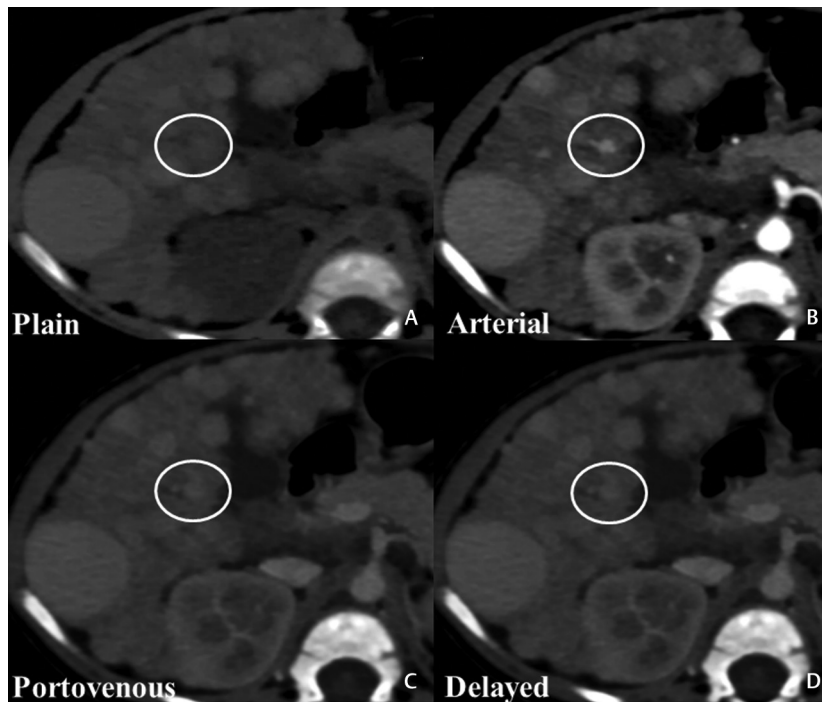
Sequential axial CT scan through the liver at a lower level. Axial noncontrast (A), arterial phase (B), equilibrium phase (C), and hepatic phase (D) images are shown. A small isodense, ill-defined observation seen in segment IVb of the liver (encircled). It shows nodular nonrim arterial phase hyperenhancement, showing subsequent washout and appearing isodense to the normal liver parenchyma on equilibrium and hepatic phases. No capsule was discernible on delayed phase: suspicious for hepatocellular carcinoma (HCC).
